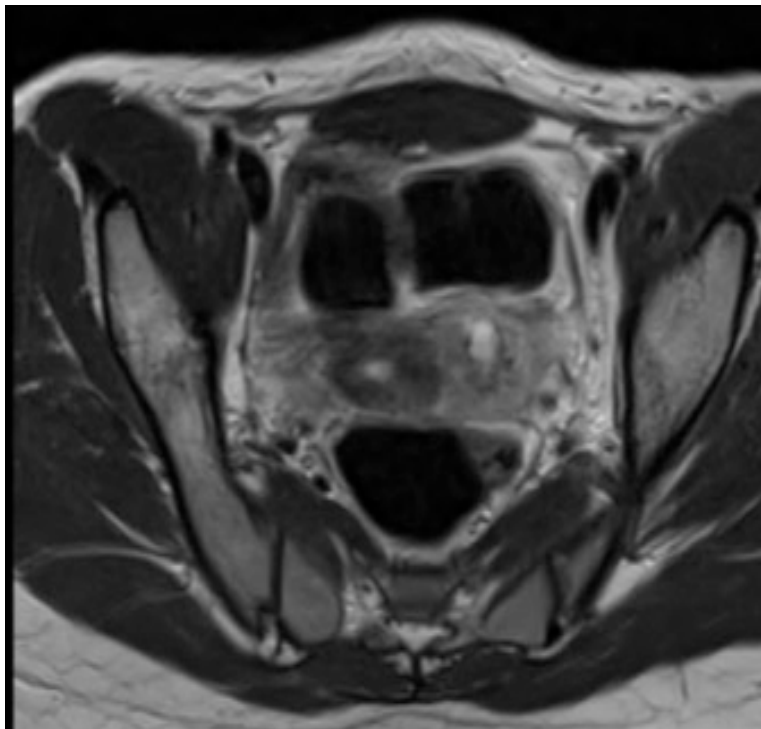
MRI Scan-large left accessory horn.
